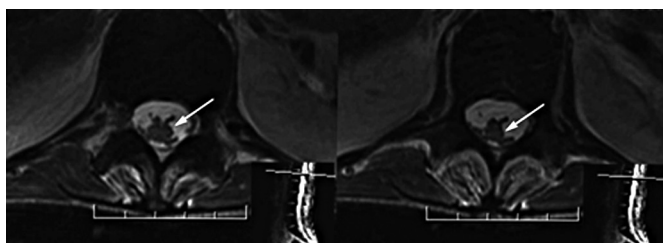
Magnetic resonance imaging of the dorsolumbar spine showed contrast enhancement of all the nerves of the cauda equina (arrows).
